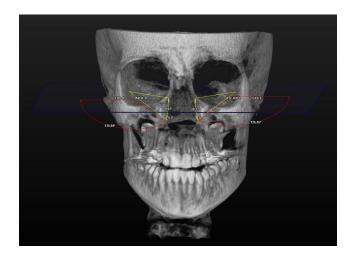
CBCT measurement of the Eustachian tube (ET) length in three-dimensional (3D) space from different views
